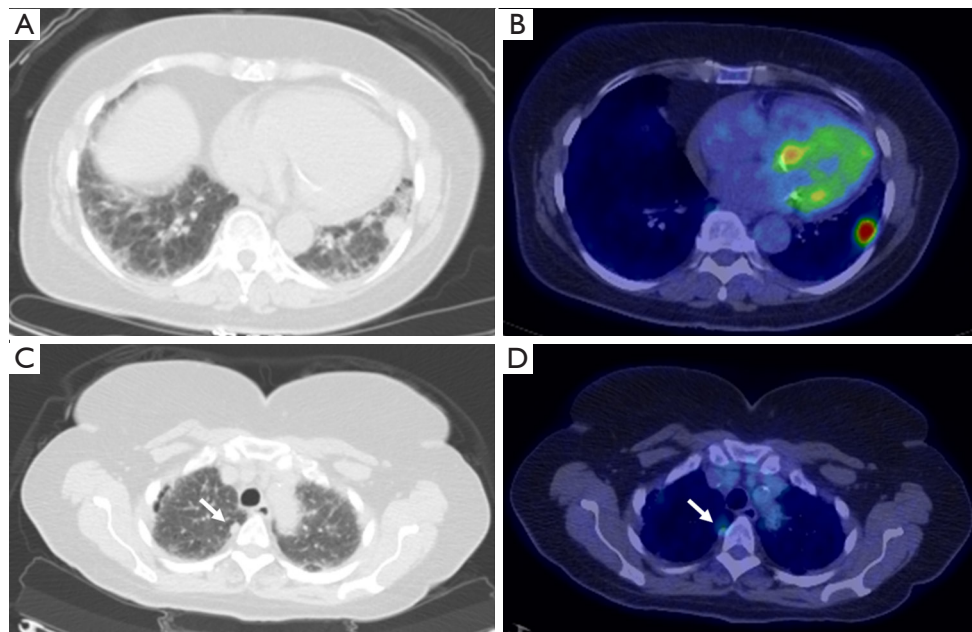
A 74-year-old woman with biopsy proven left lower lobe bronchogenic carcinoma. Index lesion is shown on axial CT image (A) with increased FDG uptake (B). Smaller right upper lobe pulmonary nodule (arrows) on axial CT (C) also demonstrates mild increased FDG uptake (D). This nodule was biopsied and confirmed to represent metastatic deposit.
